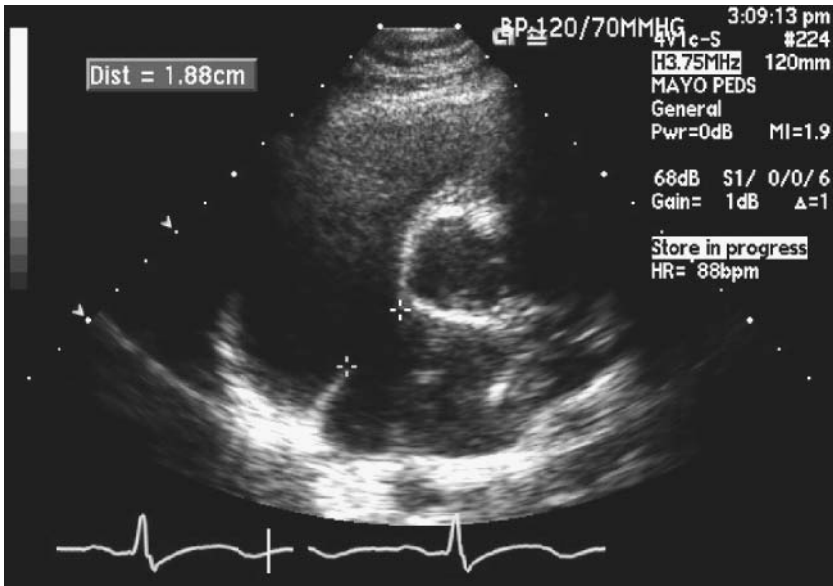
Transthoracic echocardiogram, parasternal short axis view. The atrial septal defect measures 1.88 cm.
